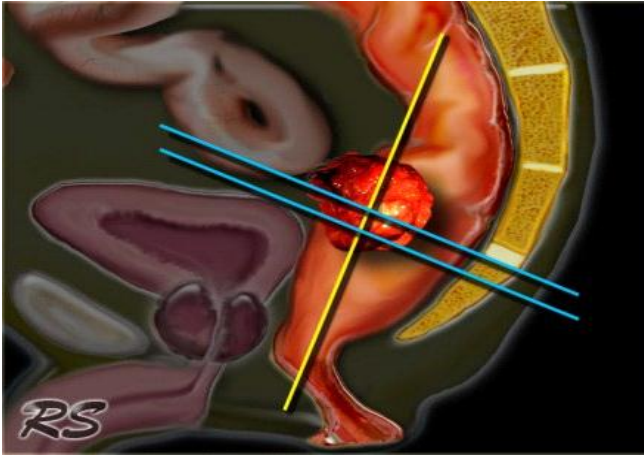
Scanning of rectal cancer with MRI
